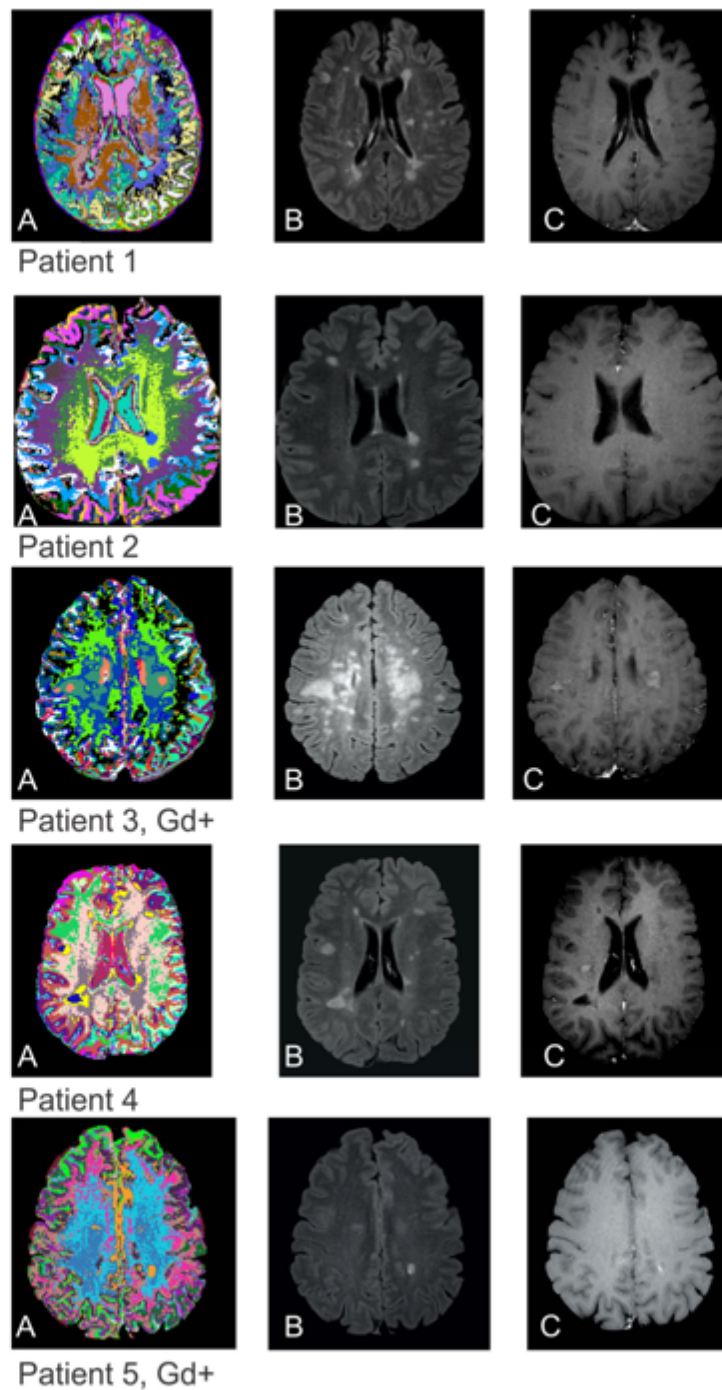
For each patient, A – SOM generated image, B – FLAIR, and C – Gadolinium T1 acquisitions. Gd+ = Patient with Gd enhancement.
